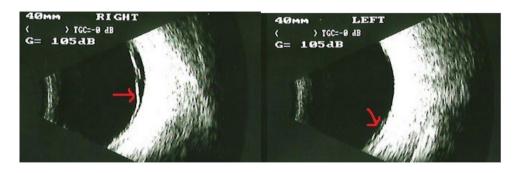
B-scan of ultrasound examination after one month showing the retinal detachment in the lower hemisphere of the retina of both eyes
